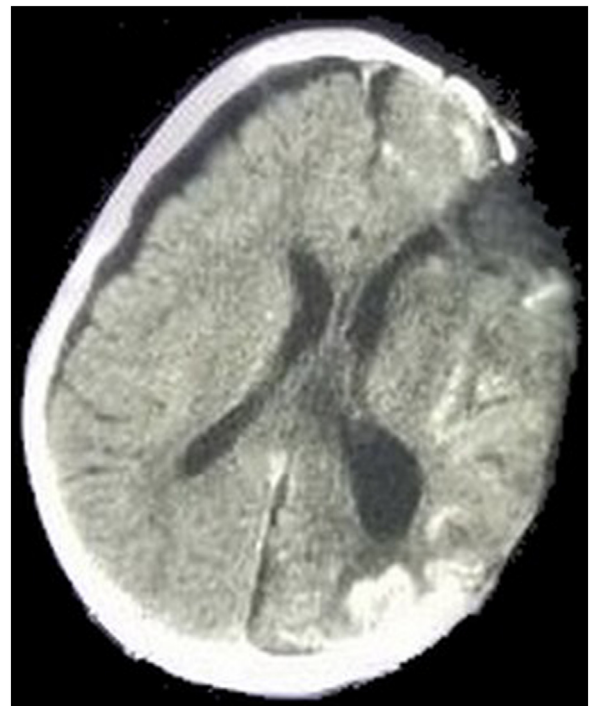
Axial section of a brain CT scan performed after decompressive craniectomy.
